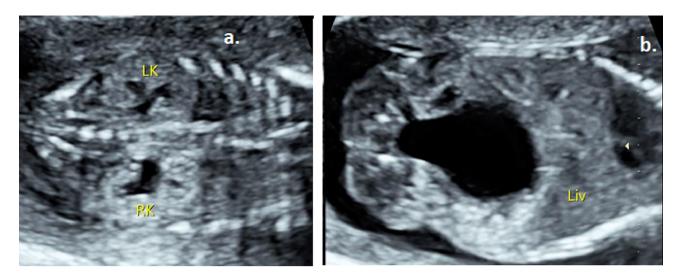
Ultrasound images before fetal surgery: demonstration of "Echogenic kidneys" (a) distended bladder with typical "key-hole" sign (b)
